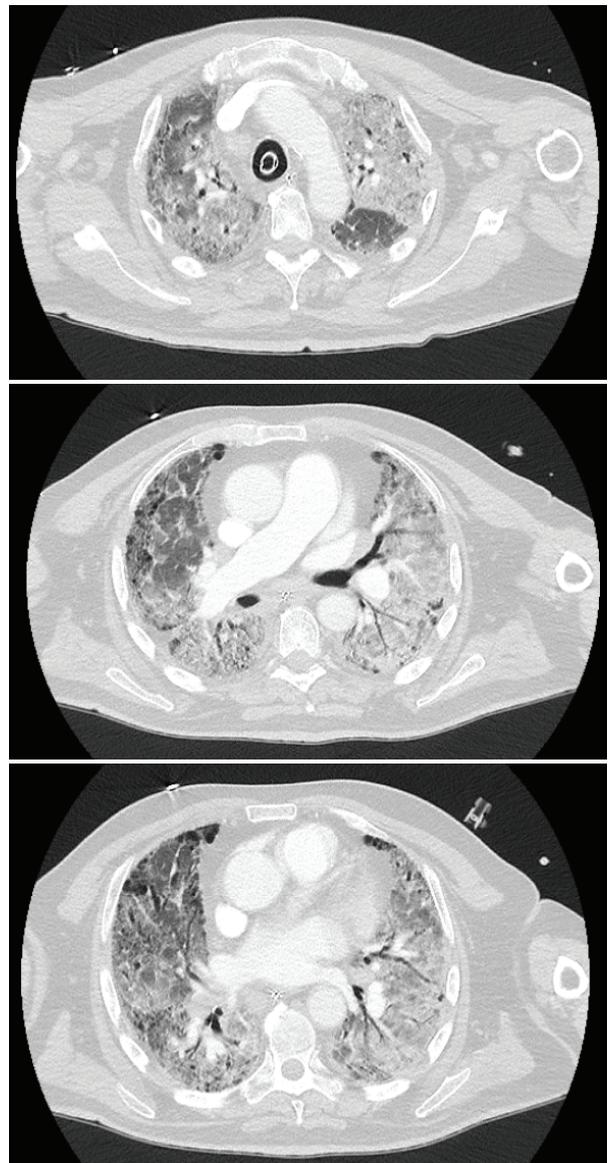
Chest CT of a ventilated patient with acute exacerbation of the previously known IPF
